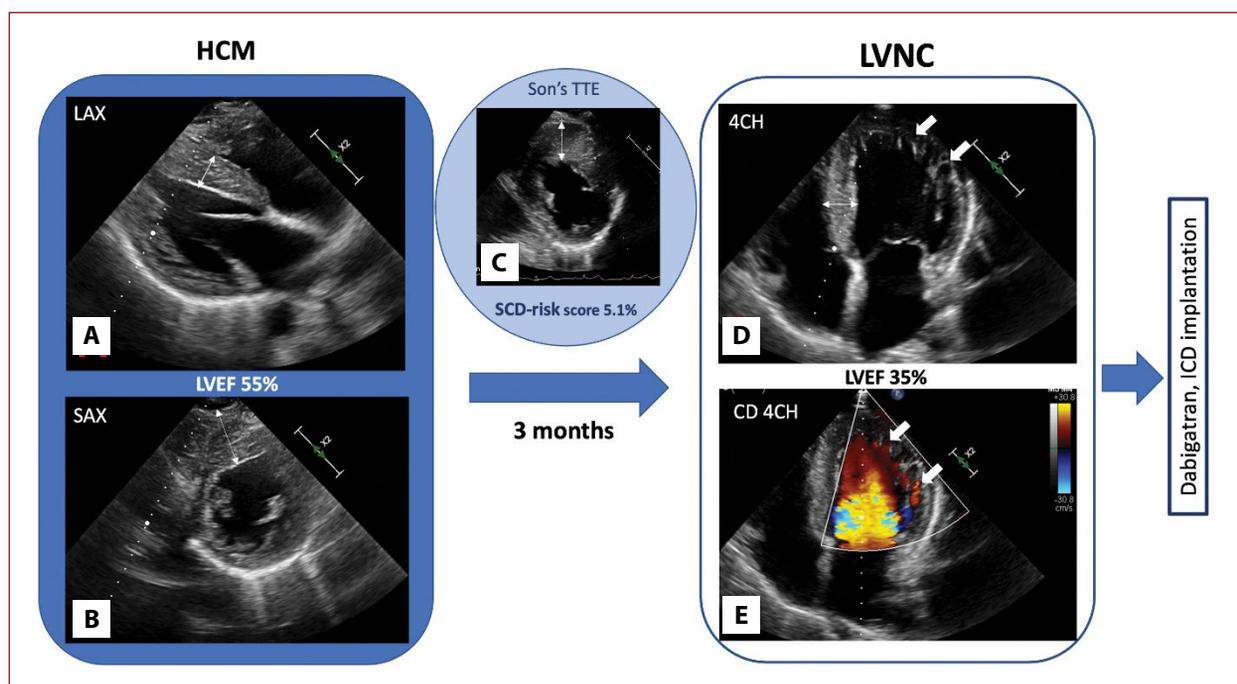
Transthoracic echocardiography (thin arrows — maximal thickness of LV segments). A. Long parasternal axis: hypertrophy of the LV wall (IVS thickness, 17 mm). B. Short parasternal axis: hypertrophy of the LV wall (maximal LV wall thickness, 24 mm). C. Short parasternal axis (echocardiography of the patient's son): hypertrophy of the LV wall (maximal LV wall thickness, 29 mm). D. Four-chamber view: the LV trabeculations (IVS thickness, 15 mm; thick arrows — trabeculations). E. Four-chamber view, color doppler: blood flow between the LV trabeculations (arrow — blood flow through trabeculations).
